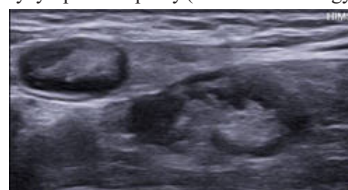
Left axillary sonogram showing multiple conglomerated necrotic lymphadenopathy of various sizes
